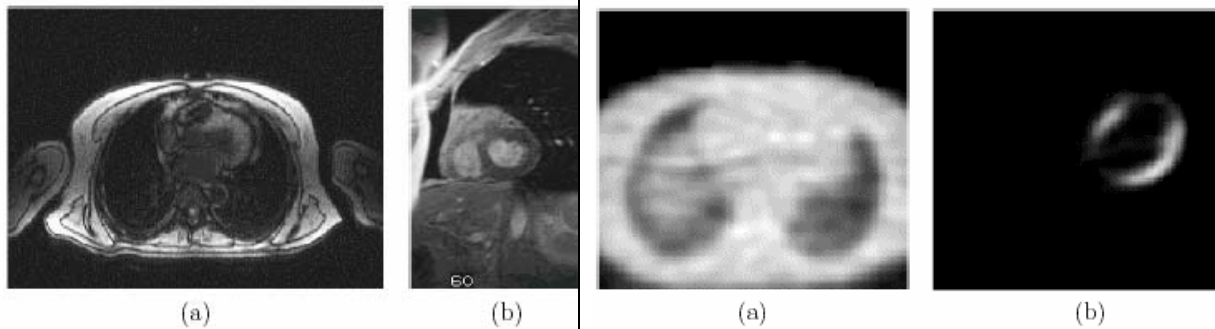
Images IRM transverses (a) et en petit axe (b). Images TEP de transmission (a) et d'émission ^{18}F -FDG (b)
